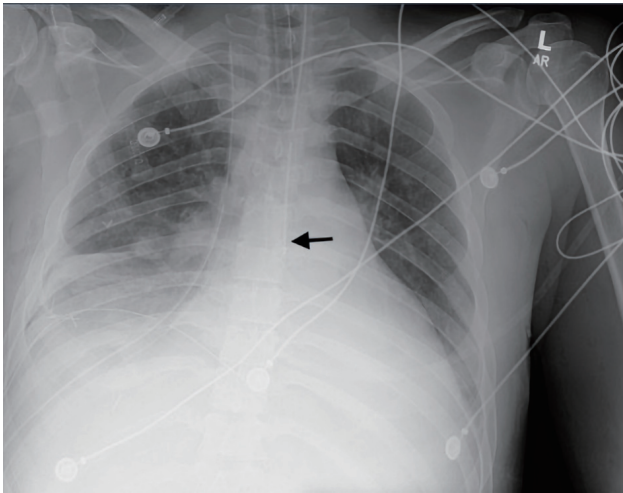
Frontal chest X-ray showing life support and monitoring devices: an orogastric tube terminates within the mid-esophagus (black arrow).
